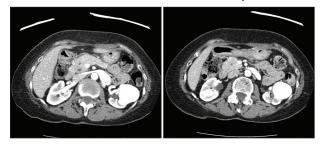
Renal mass discovered via chest CT imaging.
